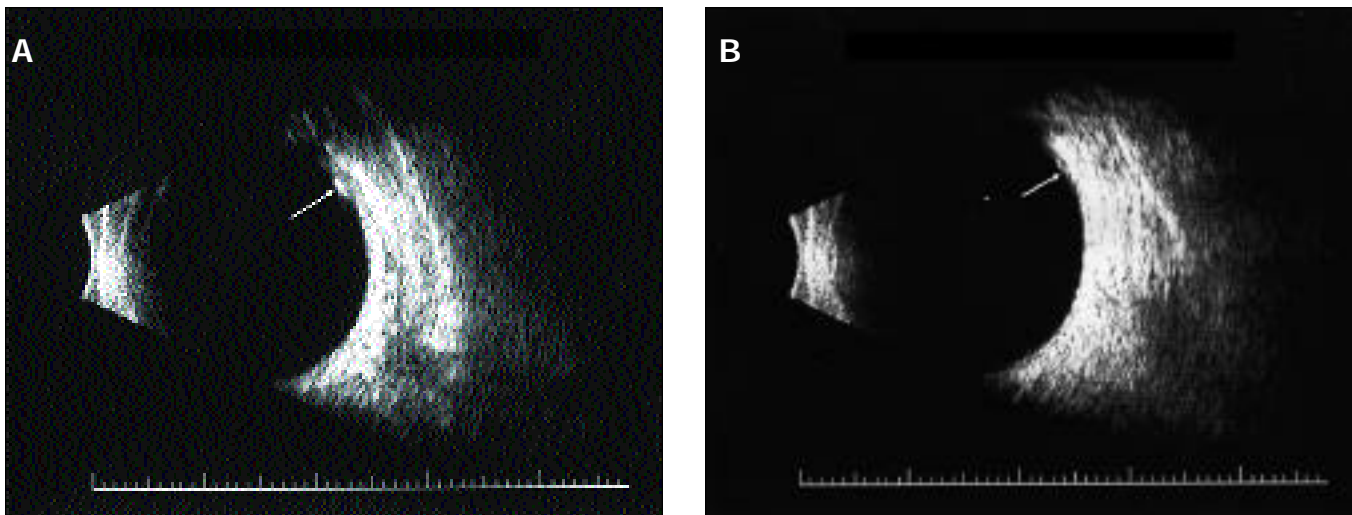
Patient 3. (A) B-scan ultrasonogram demonstrates the dome-shaped lesions expanding in upgaze.(B) Disappearance of the lesions in primary position.
